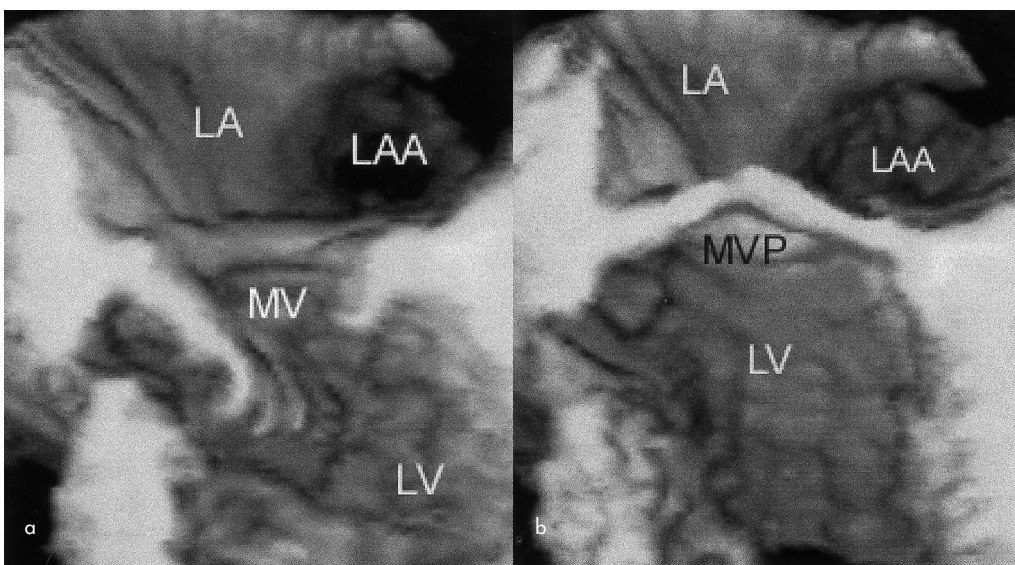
Three-dimensional echocardiographic images of the left ventricle and the mitral valve in (a) diastole and (b) systole. The mitral valve can be seen to prolapse into the left atrium in systole. MV(P) = (prolapsing) mitral valve; LA = left atrium; LAA = left atrial appendage; LV = left ventricle.
